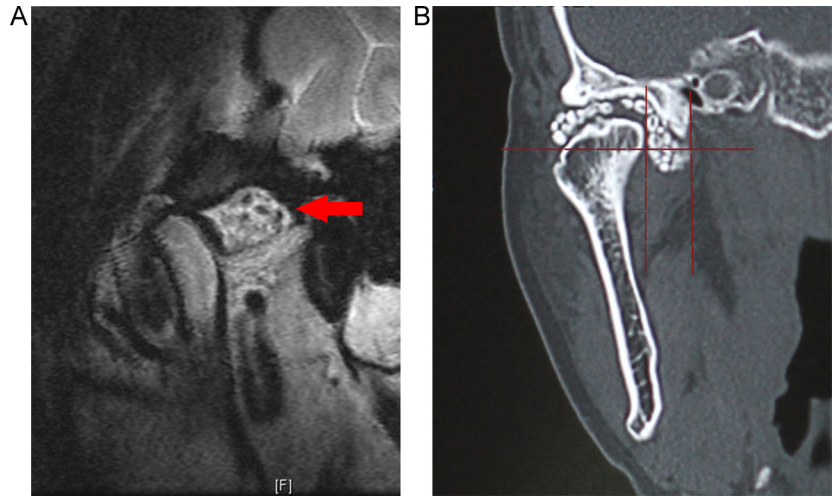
MRI and CT examinations of a patient. (A) Oblique sagittal MRI scan revealing effusion and loose bodies in the medial groove of the upper articular cavity; the appropriate condyle morphology was maintained and no bone destruction of the glenoid fossa or the articular tubercle was observed. (B) Coronal CT scan showing loose bodies distributed in the upper articular cavity, some of which had aggregated in the medial groove and had caused a bulge on the medial side of the joint capsule.
